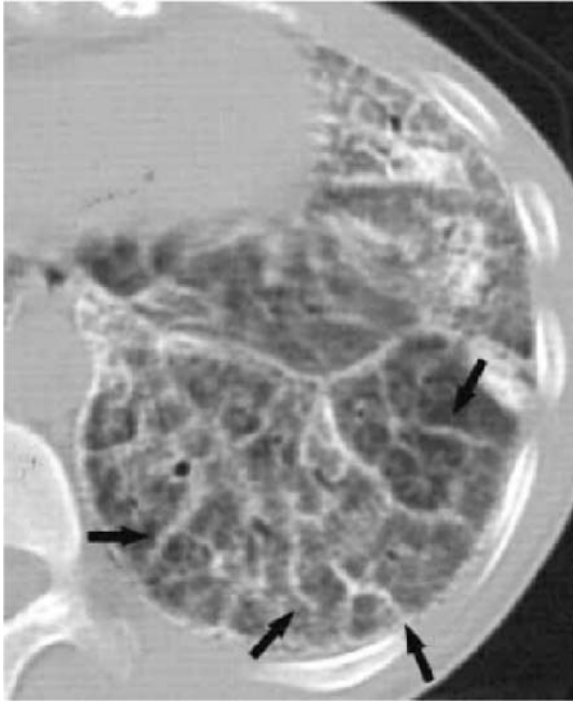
Chest CT at the diaphragm level. (a) Window level  $-300$  HU, window width  $1,000$  HU. Ground-glass opacities and consolidation are observed. (b) Window level  $50$  HU, window width  $1,000$ . Calcifications that have a reticular structure are observed in the consolidation
